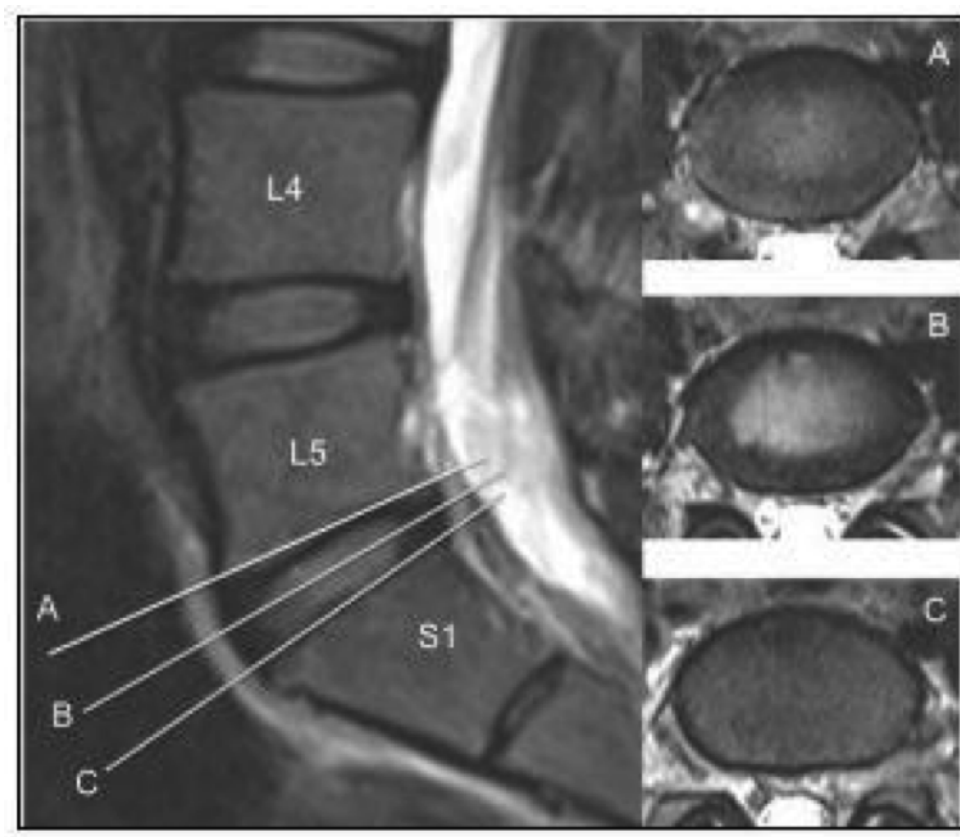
Sample of MRI scan in sagittal and transverse planes
